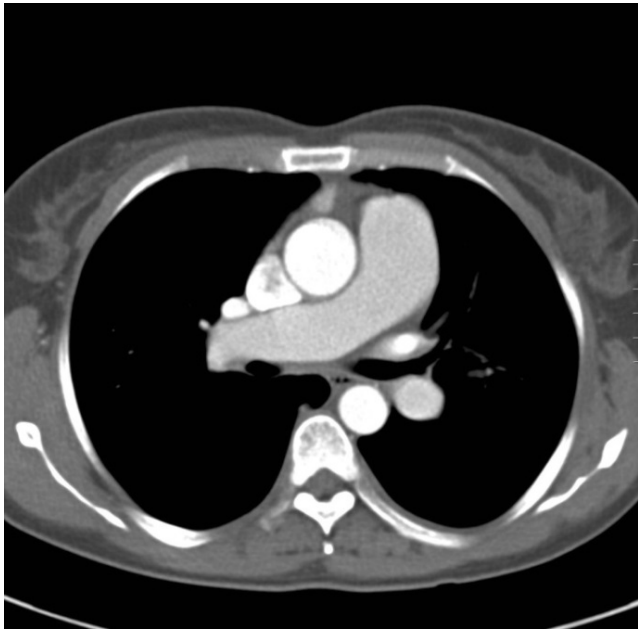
Contrast-enhanced CT of chest revealed pulmonary arterial hypertension.
